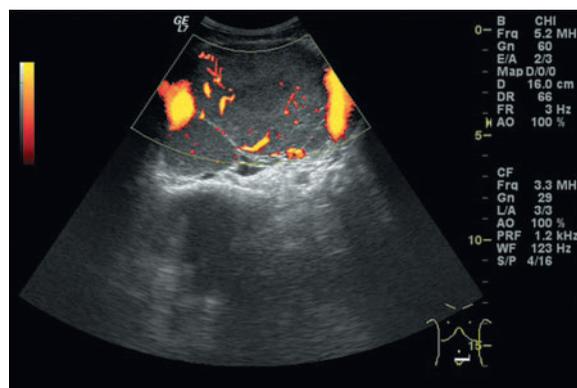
Girl WE. Transabdominal sonography of the pelvis – Power Doppler – blood vessels in the tumor.
